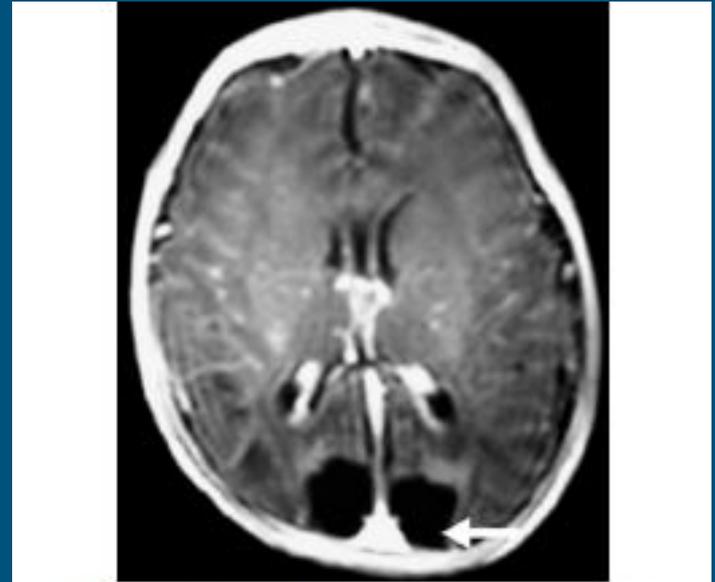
T1 weighted axial MR image of brain at level of occipital horns showing abnormal hypointense areas in bilateral occipital lobes and parieto-occipital region
